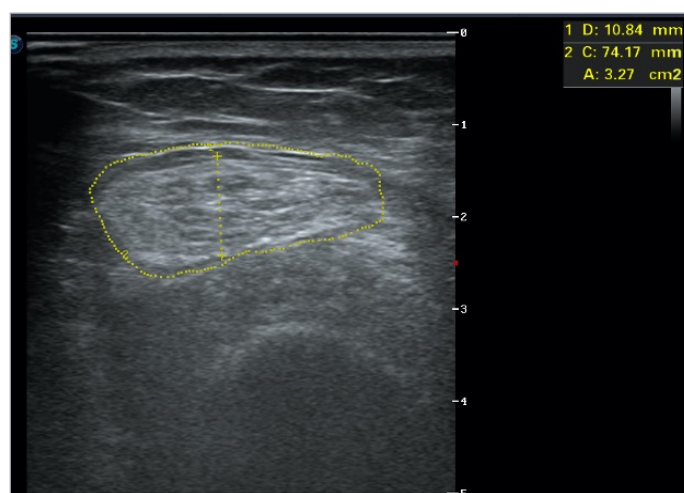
Measurement of ultrasound parameters in rectus femoris muscle.
